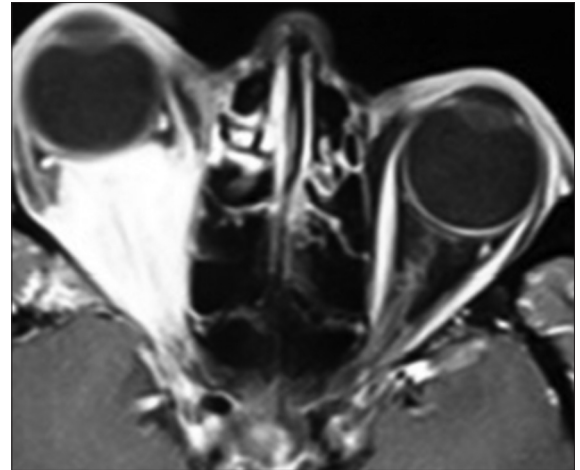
Contrast-enhanced T1-weighted magnetic resonance imaging of axial view of the right orbital retrobulbar mass
